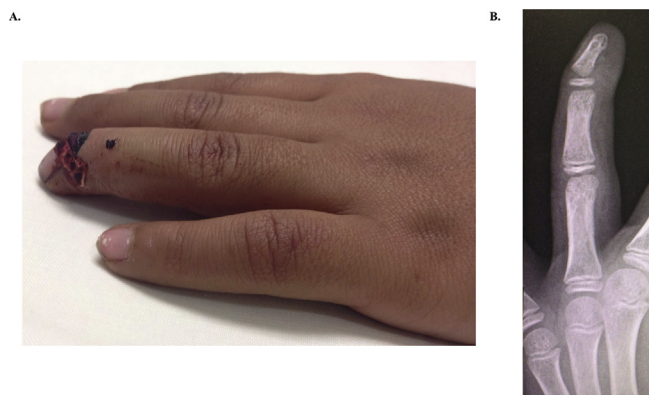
Clinical presentation of Seymour fracture. A. The clinical involvement of the left ring finger with open fracture of the distal phalanx together with nail avulsion. B. Radiographic image showing the radiologic findings with open juxta-epiphyseal fracture of the distal phalanx.
